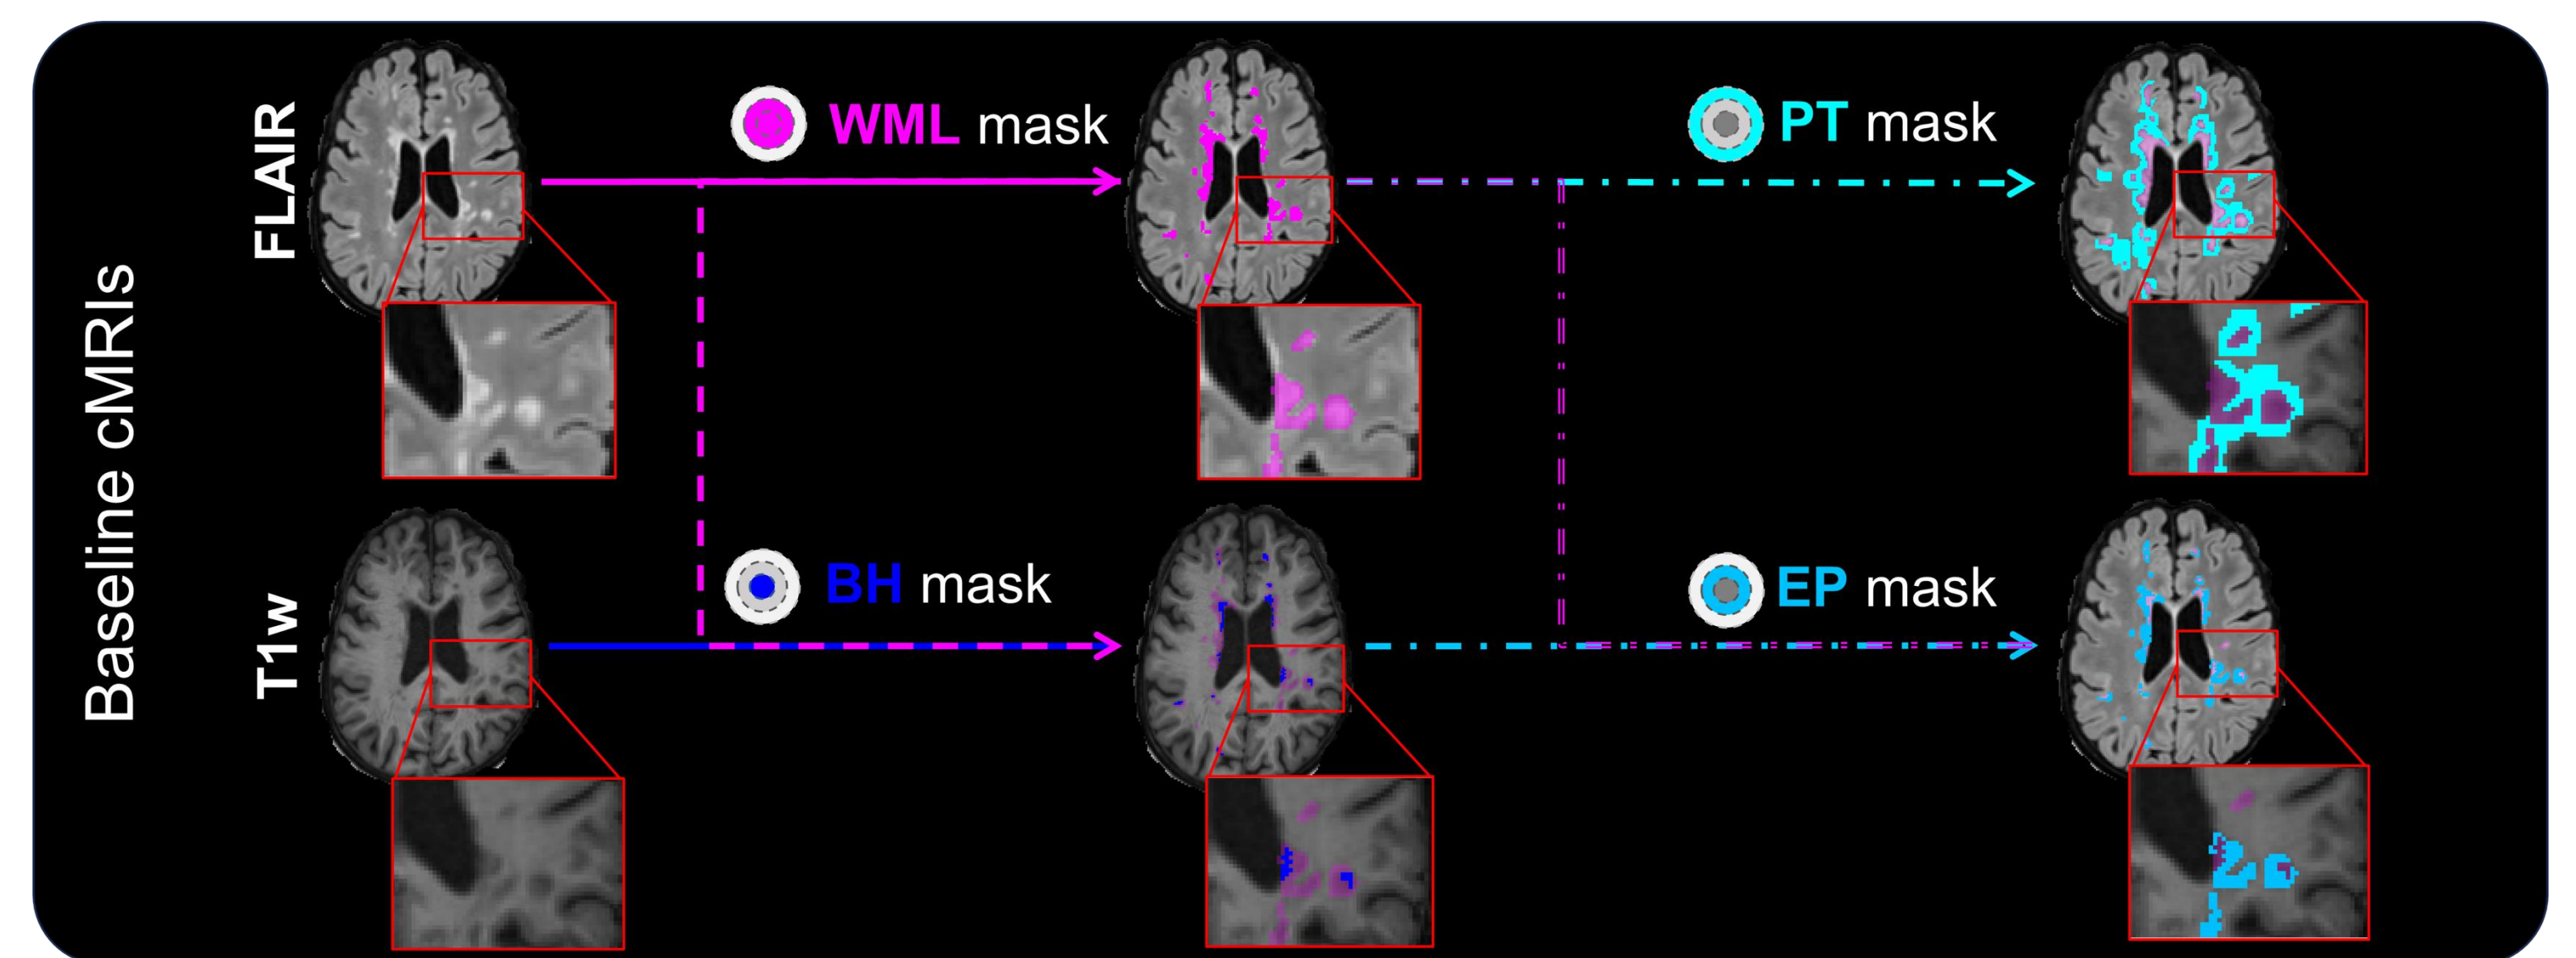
Lesion regions identification scheme. First, WML mask was identified segmenting FLAIR-hyperintensities. Then T1w-hypointensities in WML mask were identified as black hole (BH) region. Finally, external portion (EP) was defined as the region between BH and lesion edge, while peri-lesional tissue (PT) region as 2 mm-ring beyond lesion edge.
